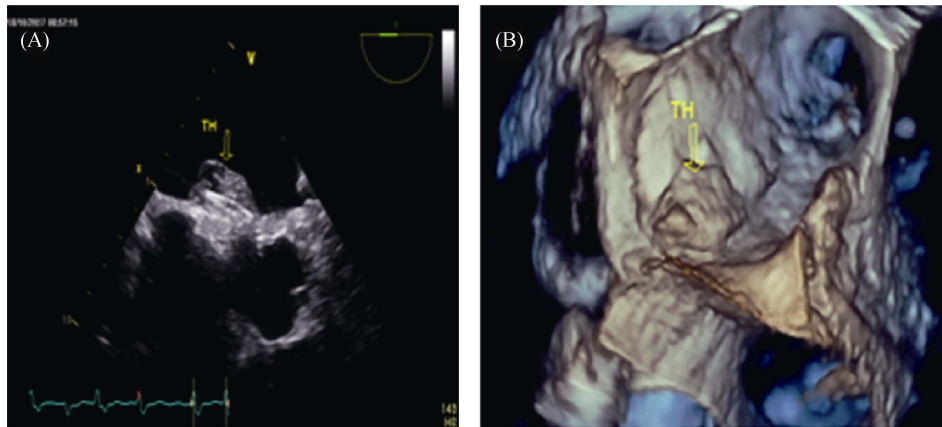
2D transesophageal echocardiograph (A) and 3D transesophageal echocardiograph (B) showing a thrombotic layer (yellow arrow) approximately 0.6 cm thick over the left atrial surface of the atrial septal defect occluder.
